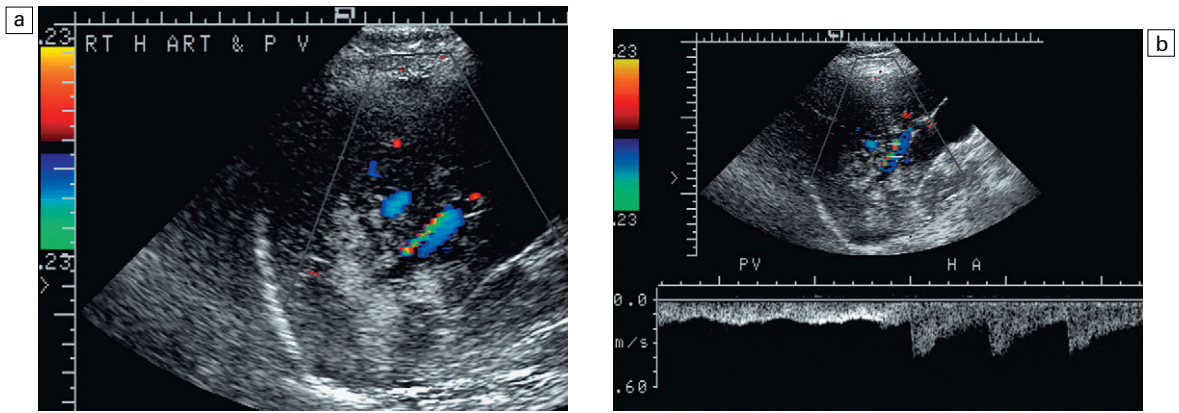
(a) Transverse image of the right lobe of the liver. A globular but very echogenic mass like infiltrate is perceived in the inferior aspect of the right lobe. The posteroinferior branch of the right hepatic artery and vein are seen coursing into this area on colour Doppler. (b) Spectral Doppler tracing of the hepatic artery and portal vein supplying this mass reveals the velocities are relatively normal. The ratio of flow is not altered between the two vessels. Biopsy proved this mass to be focal fatty infiltration.
